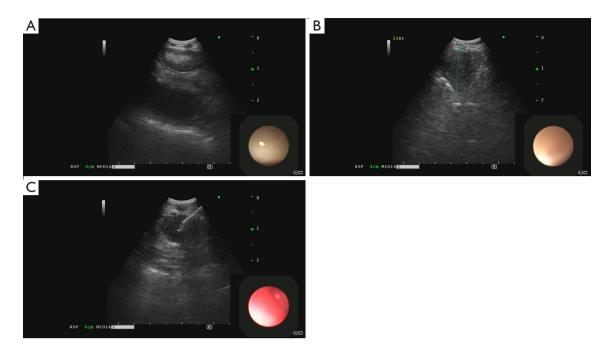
Characteristics of malignant lymph nodes on EBUS. (A-C) Examples of B-mode (gray scale) lymph nodes that are greater than 1 cm on the short axis, round/heterogenous shape, and a distinct margin, all concerning qualitative signs of malignancy. (A) EBUS 2D mode view of mediastinal lymph node. (B) EBUS 2D mode view with measurements of mediastinal lymph node. (C) Realtime EBUS view of the needle during TBNA of a mediastinal lymph node. EBUS, endobronchial ultrasound; 2D, two dimensional; TBNA, transbronchial needle aspiration.
